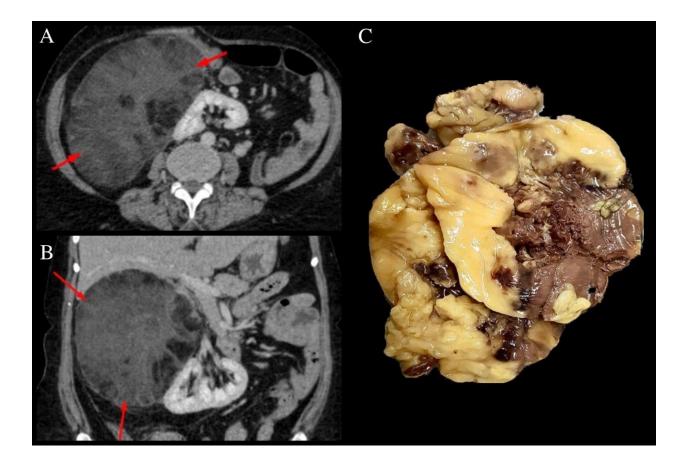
(A+B) CT image showing well circumscribed, mixed density lesion.
